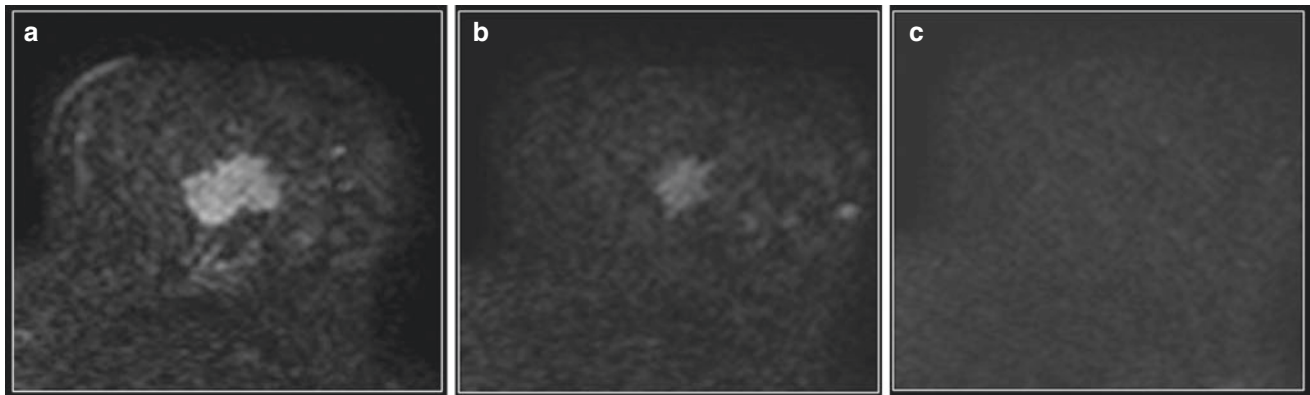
Use of diffusion-weighted imaging for response assessment. (a) Baseline, (b) Mid-treatment and (c) After treatment. Note on (a) the bright signal on DWI at baseline, due to diffusion restriction secondary to the high cellularity of cancer. At mid-treatment (b), the cytotoxic effects lead to reduced cellularity of the tumor, such that
